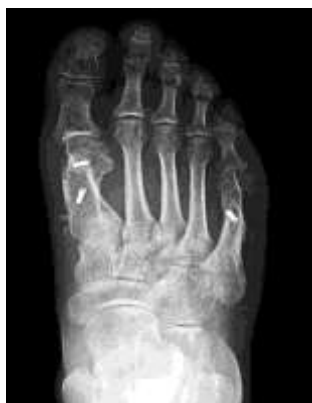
Postop radiograph after 12 months with bone fusion
